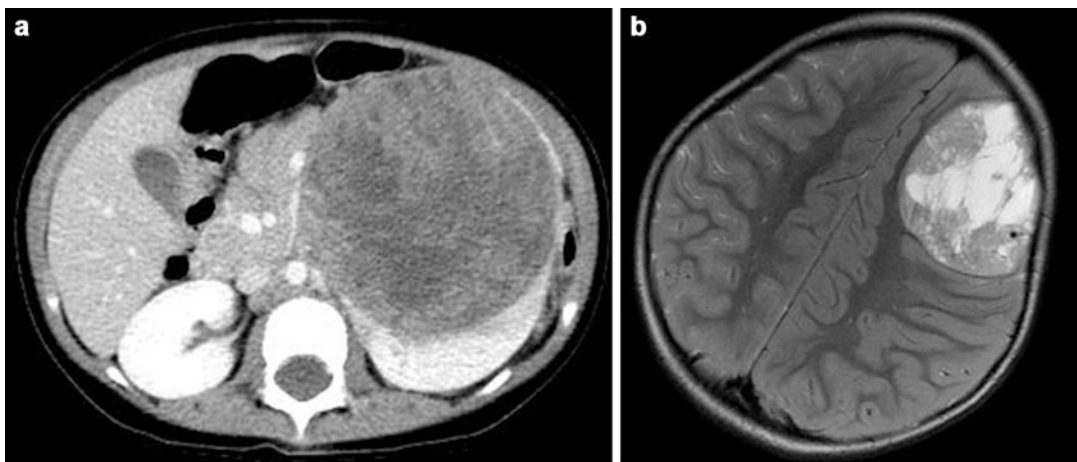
(a, b) A 2-year-old female with a left renal mass was seen on the recent ultrasound. CT scan demonstrated a large heterogeneous mass arising from the left kidney (a). A heterogeneous metastatic lesion was present in the right front lobe of the brain (b). The masses were confirmed as Wilms' tumors (Courtesy of Dr. Grace Guo)
